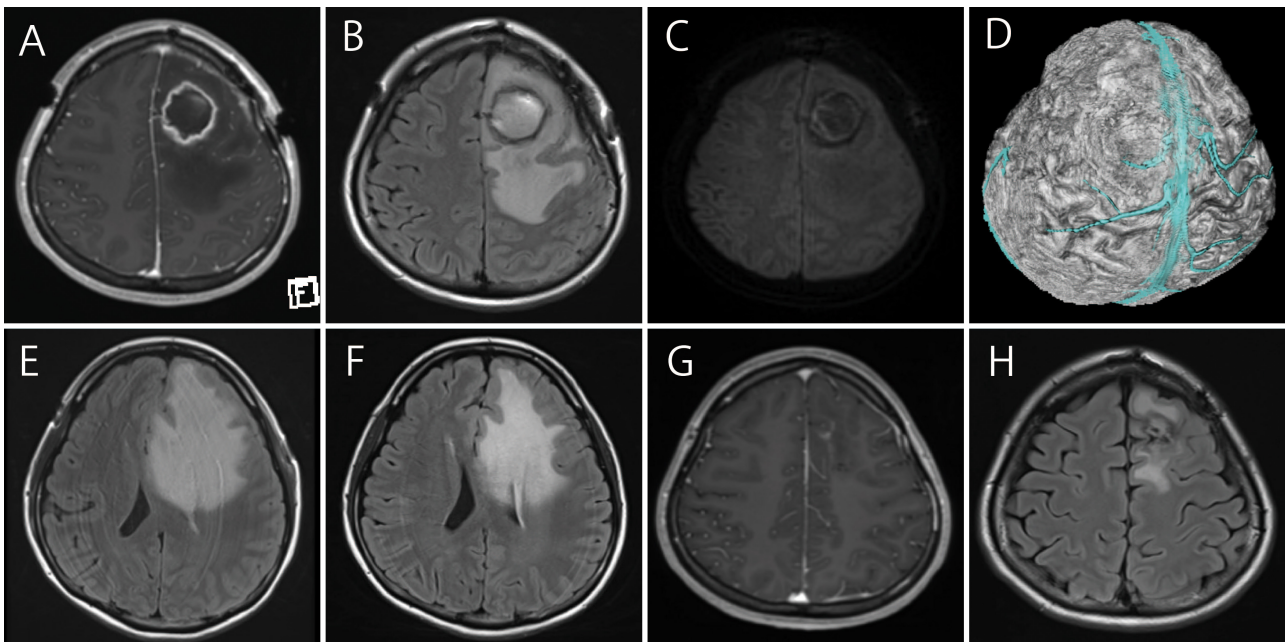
Six days postoperatively, an axial gadolinium-enhanced T1-weighted image (A) showed perilesional enhancement, and an axial fluid-attenuated inversion recovery image (B) showed posteriorly enlarged perifocal edema compared with panel D. There was no new cerebral infarction around the lesion on diffusion-weighted imaging (C) and no obvious major venous occlusion (D). The midline shift and edema improved from postoperative day 6 (E) to day 13 (F). Three months postoperatively, perilesional contrast enhancement (G) and edema on the axial fluid-attenuated inversion recovery (H) images had diminished significantly.
